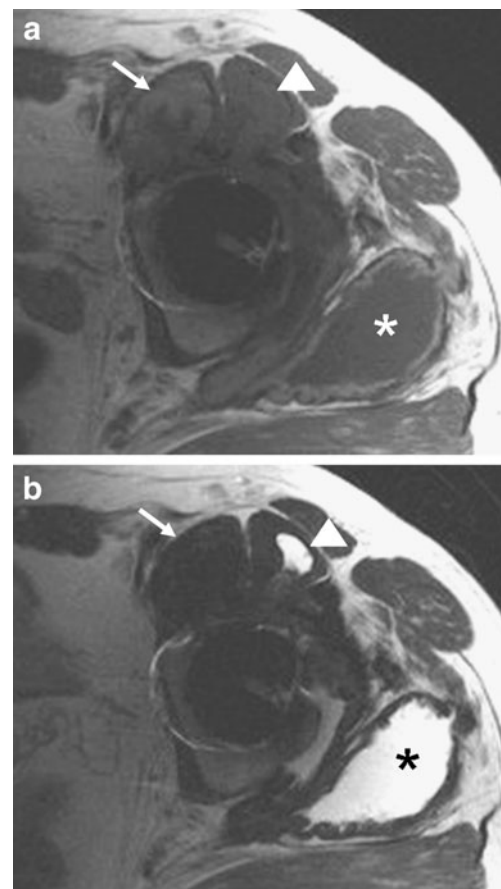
a T1-weighted and b T2-weighted MRI showing reactive masses. Anteriorly there is a solid mass (*arrow*) and a mixed cystic-solid mass (*arrowhead*). Posteriorly there is thick-walled cyst (*asterisk*). All the solid components show low signal on the T2-weighted images and signal that is slightly higher than muscle on the T1-weighted images
